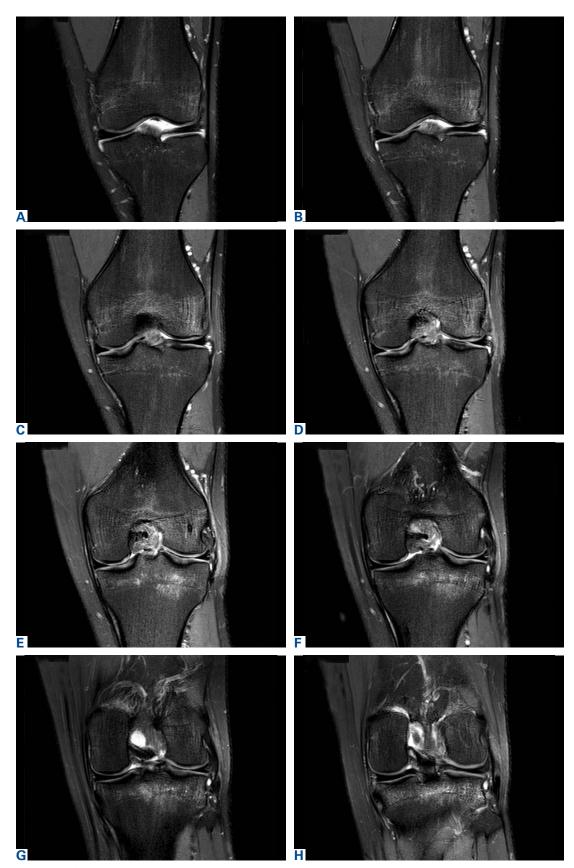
(A-H) Anterior to posterior magnetic resonance imaging slices show the meniscomeniscal ligament running from the anterior horn of the medial meniscus to the posterior horn of the lateral meniscus.
